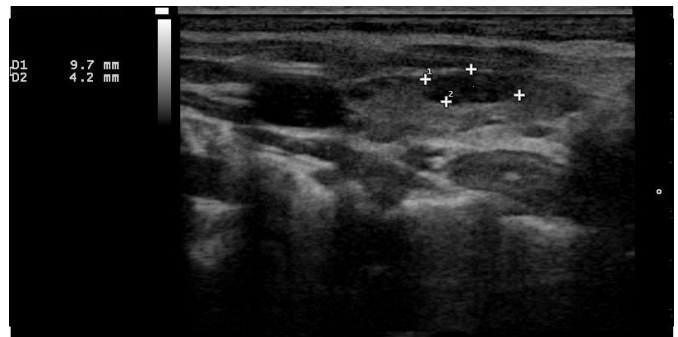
Left longitudinal B-mode ultrasound image of the neck. A well-defined hypoechoic nodule with linear and dot-like echoes is seen at the mid-pole of the left thyroid lobe measuring 9.7x4.2mm.
